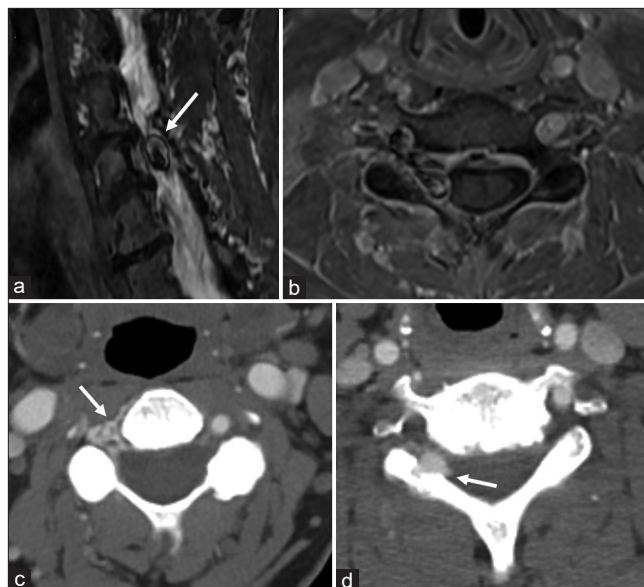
(a) Sagittal short T1 inversion recovery (STIR) magnetic resonance (MR) image demonstrates flow related artifact along the right lateral aspect of the spinal canal at the C5–C6 level producing a lamellated chemical shift appearance (arrow). (b) Axial volumetric T1 fat suppressed post contrast MR image at the level of the C5–C6 foramen demonstrating asymmetric extradural enhancement throughout the right C5–C6 neuroforamen and right lateral epidural space with local mass effect. Flow related artifact is also demonstrated, similar to what was seen on the sagittal STIR. (c) Axial contrast-enhanced computed tomography angiography (CTA) image at the C3–C4 level demonstrates asymmetric enhancement of the venous epidural enhancement surrounding the vertebral artery in the transverse foramen as well as along the right lateral aspect of the spinal canal (arrow). (d) Axial CTA image at the C5–C6 level demonstrates a focal extradural venous pouch, partially insinuating into the adjacent bone (arrow).
